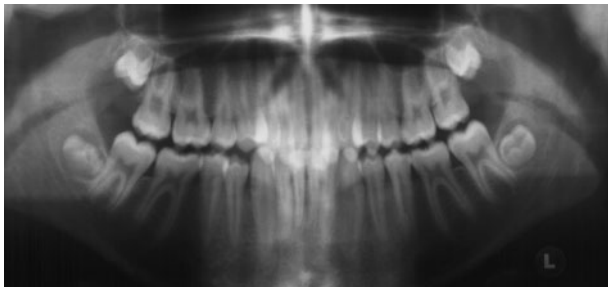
Case report 2: pre-treatment panoramic radiograph
